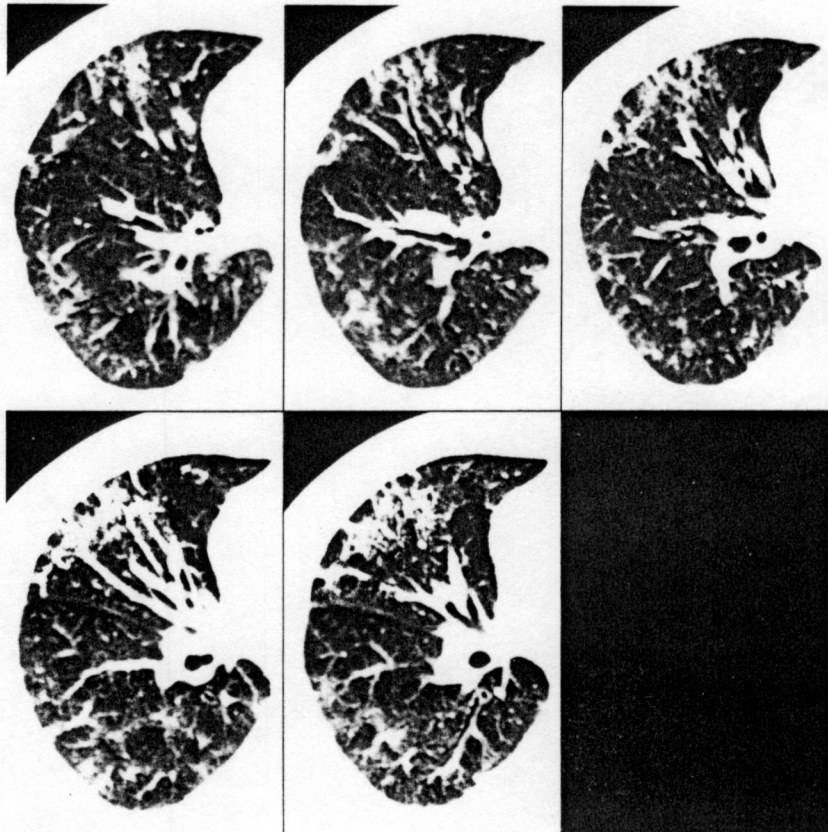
High resolution lung CT was performed on a 72-year-old man with suspected acute pulmonary fibrosis. Arterial blood gas analysis at the examination while breathing oxygen via nasal cannula at the flow rate of 6 L/min was pH 7.457, P_{CO_2} 35.7, P_{O_2} 79.3. Five serial scans make it possible to distinguish small arteries from nodular lesions.
